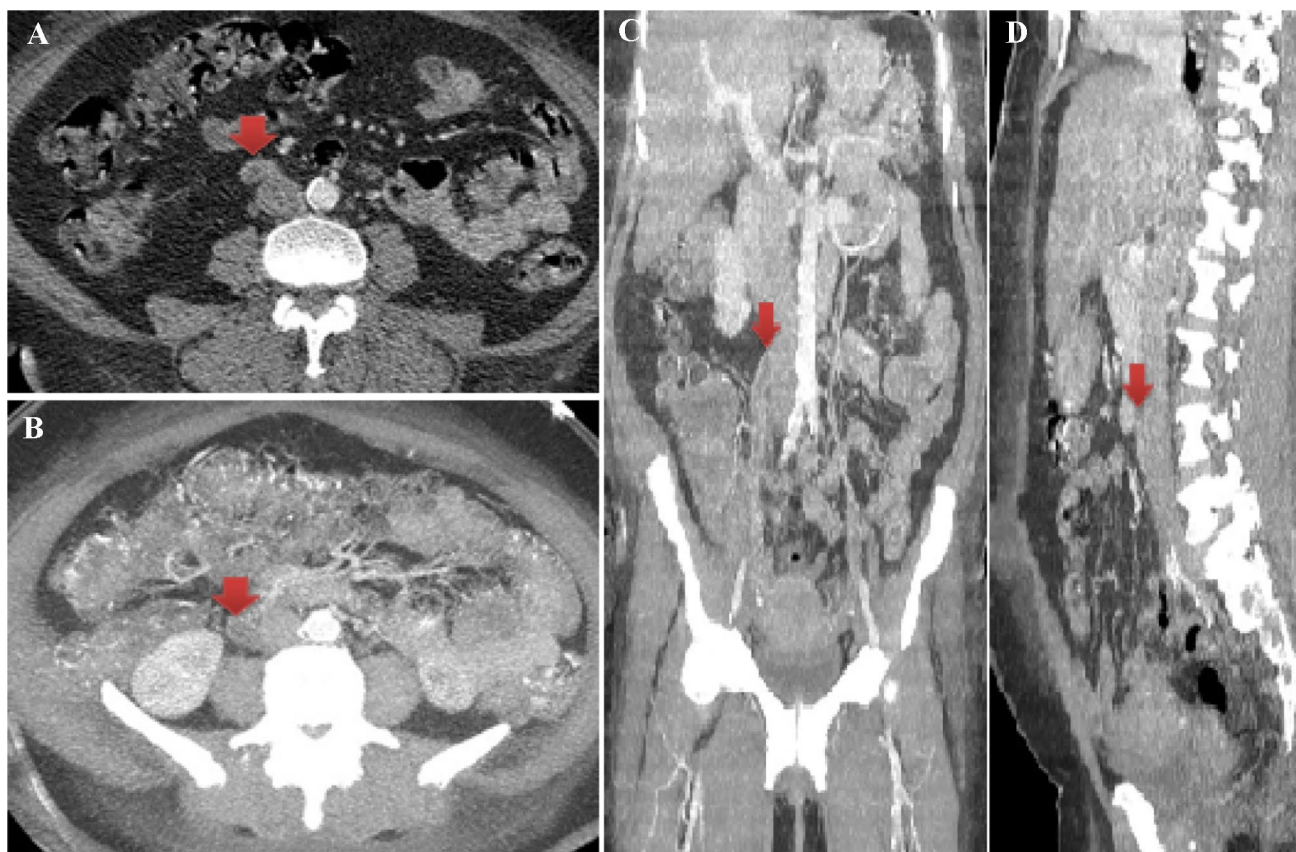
Axial (a, b), coronal (c) and sagittal (d) image of abdominal CT scan showing ovarian vein thrombosis (OVT)
